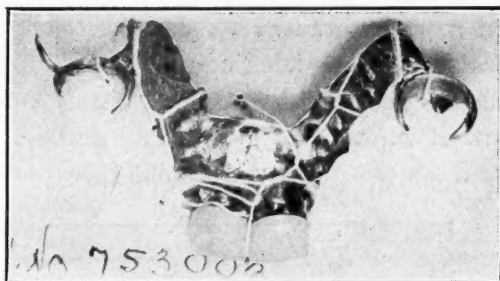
J. P., patient aged twenty-five years. Tooth plate. In situ 5 days. Swallowed during sleep. Diagnosis made by x-ray picture, and the foreign body was located in the esophagus, below the cricopharyngis. Symptoms were inability to swallow even fluids. Previous attempt at removal, elsewhere, had been unsuccessful. Removed by esophagoscopy with no anesthesia. Results: Patient cured.
